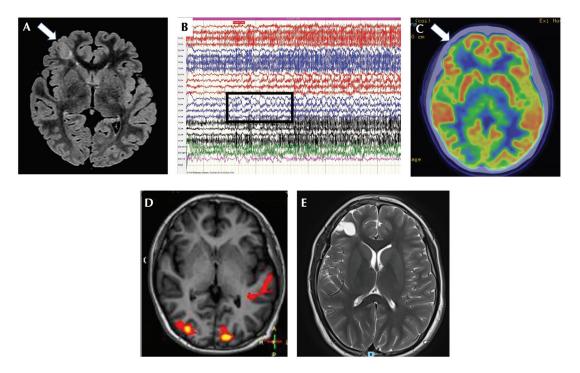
Pre-surgical evaluation for Patient 1. Representative images from Patient 1, a 12-year-old with Tuberous Sclerosis who underwent lesionectomy for Right Lateral Frontal lobe epilepsy. MRI FLAIR showed a right frontal lesion (A; arrow) that corresponded with F4 discharges on EEG (B; box) and hypometabolism focus on PET (C; arrow). EEG (B) showed rhythmic 2-2.5 Hz delta activity reversing F4 and F3, spreading to involve F8, consistent with a right frontal lobe onset. Clinically, she "raised her upper limbs, turned her head to the right while abducting lower limbs". Functional MRI (colour overlays) performed for pre-surgical planning showed speech localising to the left side (D). Post-surgical T2-weighted MRI showed the excision of right frontal lobe epileptic focus (E).
